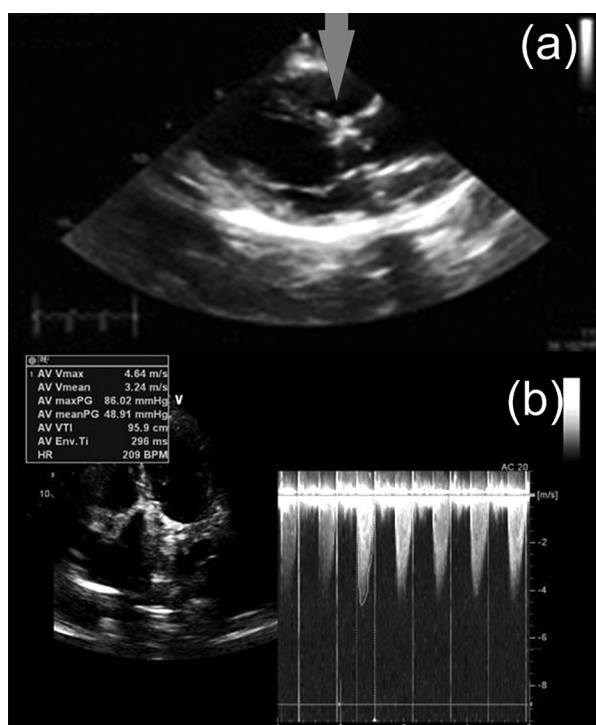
Transthoracic echocardiography: a) Arrow points to the immobile leaflet of the prosthetic aortic valve with a thrombus; b) Elevated maximal (86 mmHg) and mean (49 mmHg) gradients across the prosthesis
